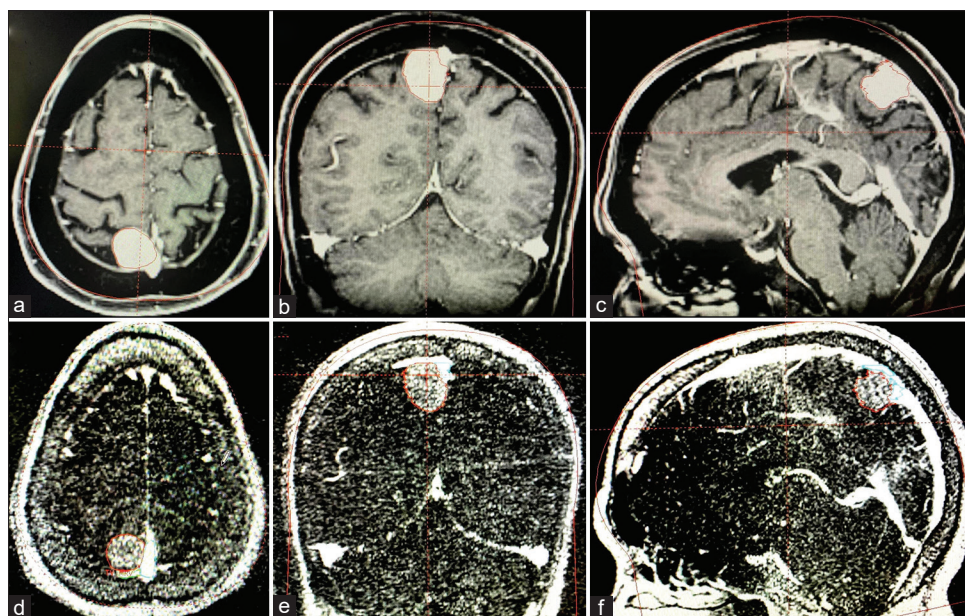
(a-c) showing right middle third parasagittal meningioma in axial, coronal, and sagittal contrast T1W MR images. The enhancement of tumor appears similar to superior sagittal sinus and cortical veins. (d-f) postcontrast magnetic resonance venogram images showing the same lesion in the axial, coronal, and sagittal plane. Note the differential enhancement of tumor, superior sagittal sinus, and cortical veins. Adjacent cortical veins and sinus is marked as risk on magnetic resonance venogram
